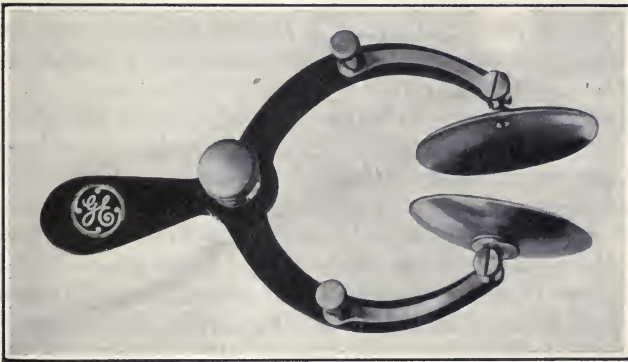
Scrotal electrode. (Courtesy of General Electric X-ray Corporation.)
